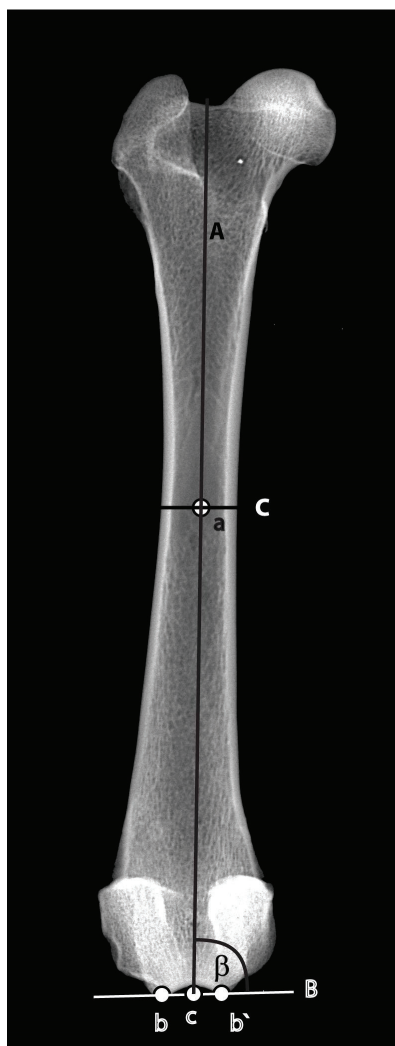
Morphometric assessment of the anatomic femoral beta angle ( $\beta$ ) (Cranio-caudal radiograph of the femur). Anatomic femoral axis (A) was defined as a line connecting the centres of the midshaft of the femur (a) and the trochlea (c), and as a tangent to the femoral condyles (B), a line connecting the distal prominences of femoral condyles (b and b')
